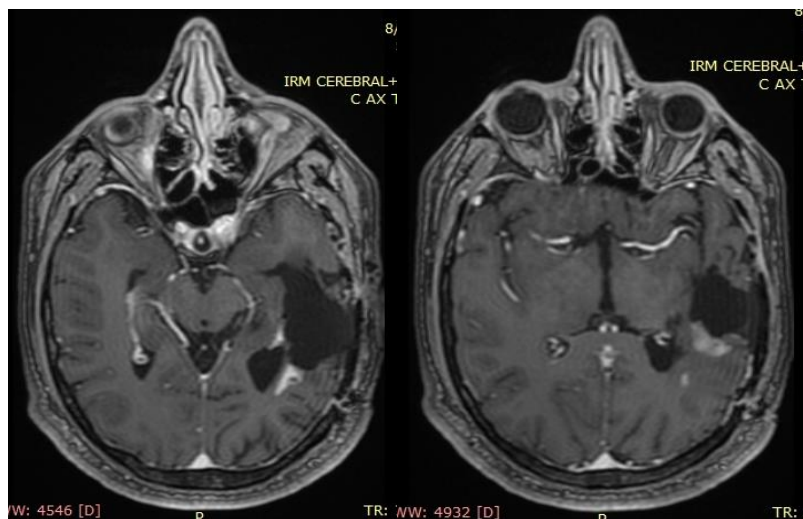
MRI aspect 2017
